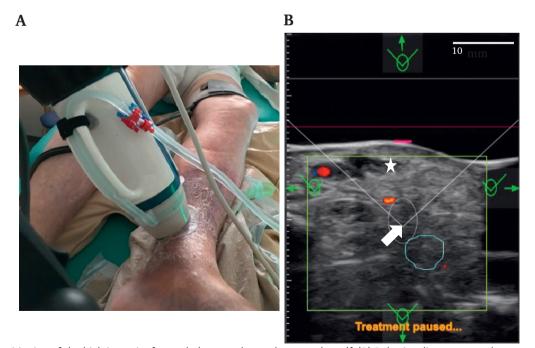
(A) Positioning of the high intensity focused ultrasound transducer on the calf. (B) Robotic adjustment on the treatment screen of the therapy transducer position. To be properly centred on the targeted vein (white arrow), the focal point position is adjusted with the green directional command arrows. Note here the presence of the subcutaneous infiltration (white star) creating depth between the skin (pink line) and the anterior vein wall.
